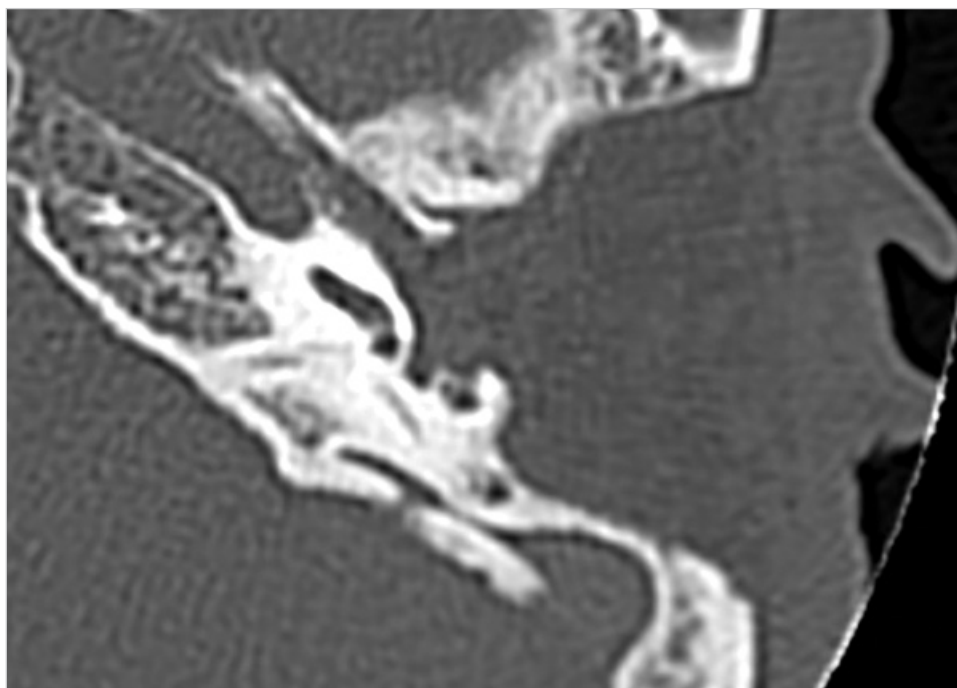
The postoperative CT shows enlarged and rounded cavity packed with abdominal fat.
